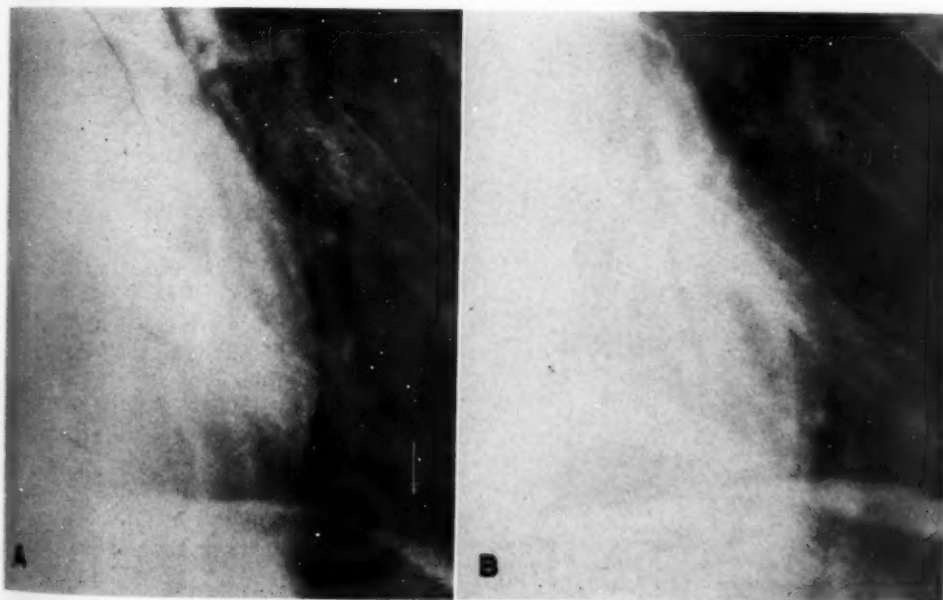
A. Routine chest roentgenogram, showing the left lower medial portion. The normal lung markings of the lower lobe appear through the heart as white lines.
